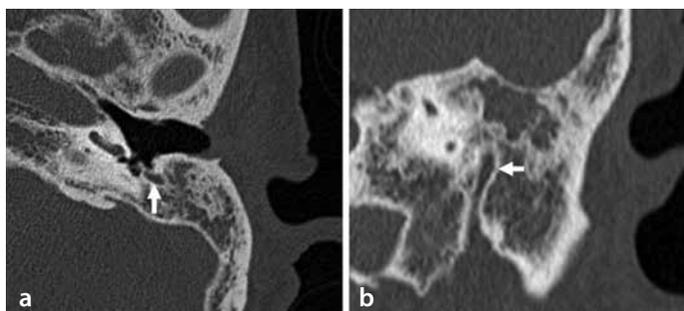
a, b. Pre-operative high-resolution computed tomography scan of the left temporal bone. The cholesteatoma extended into a small, dense, sclerotic mastoid cavity. Axial (a) and coronal (b) CT scans showed no evidence of large defects or bony dehiscence of the descending portion of the facial nerve (arrows)
